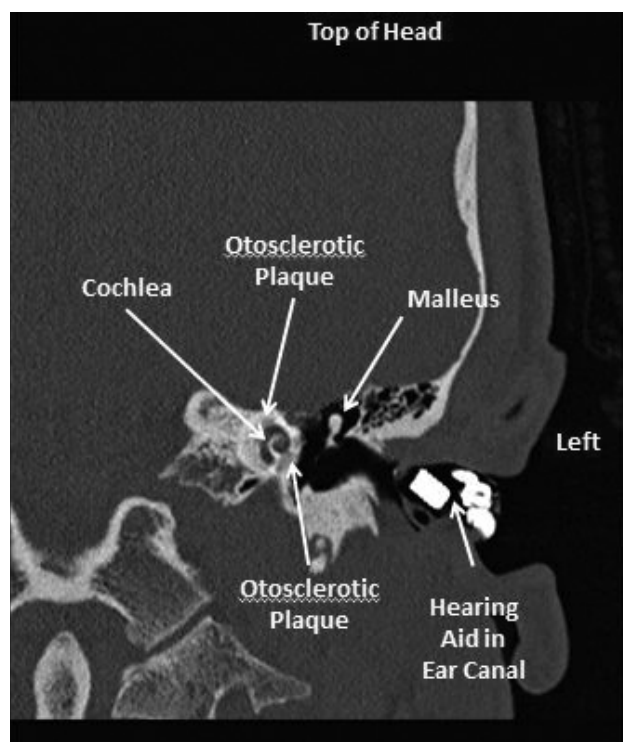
Coronal CT image of the temporal bone showing cochlear involvement by the otosclerotic plaque.
